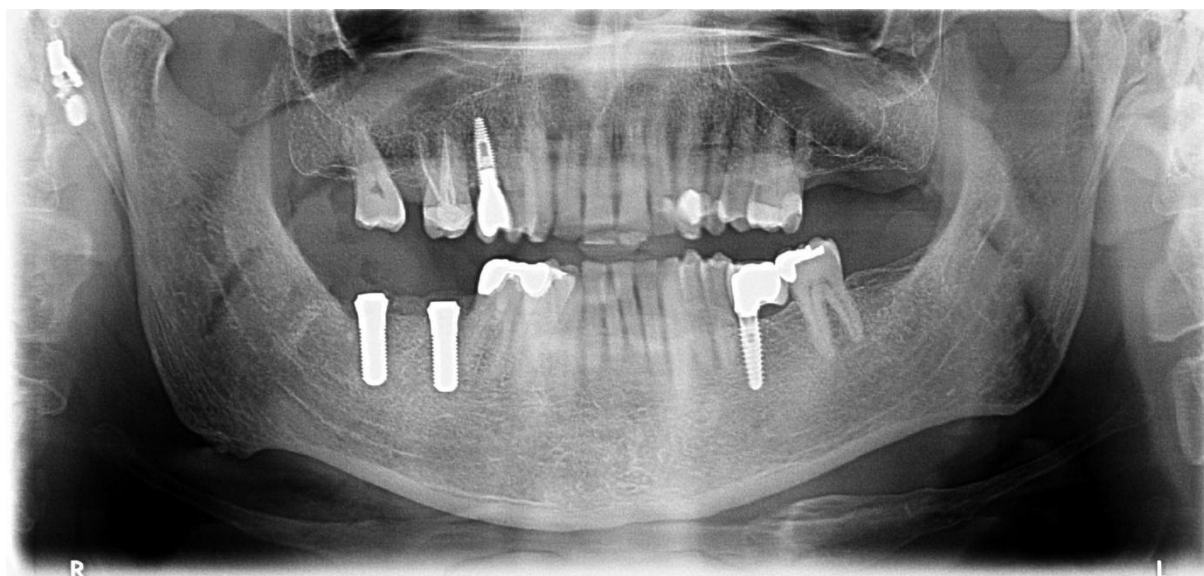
Radiograph with implant placement, after 3 months of procedure for NICO
